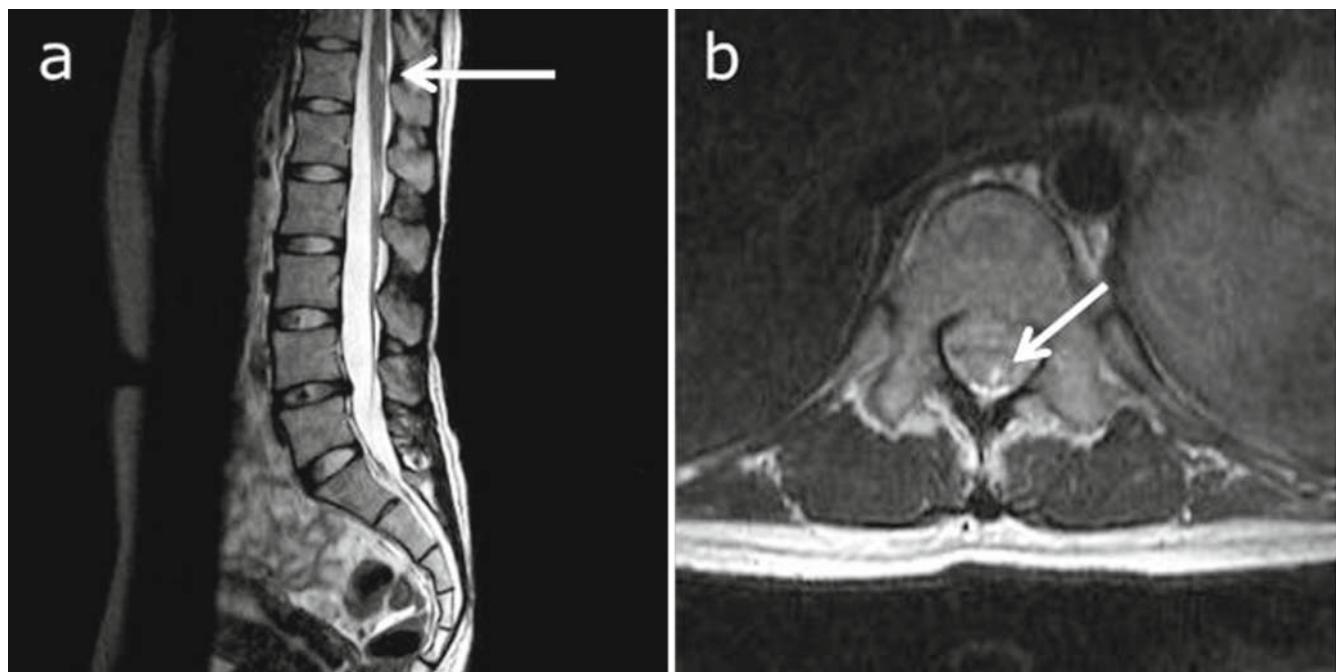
T2 weighted sagittal (a) and axial (b) magnetic resonance images depicting a small high-intensity area (arrows) in the dorsal left aspect of the spinal column at Th12
